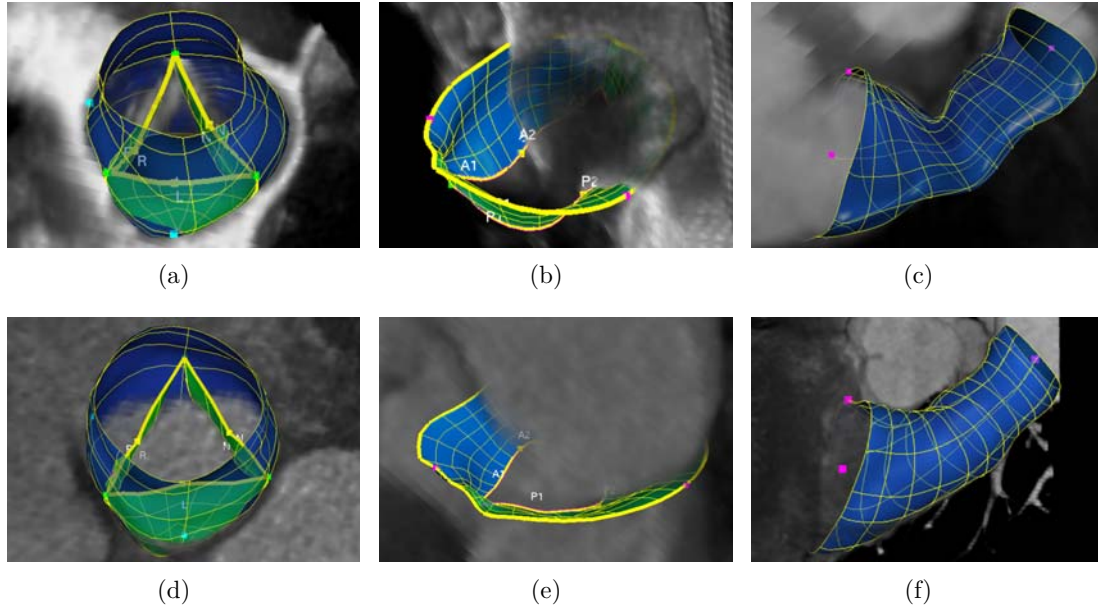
Examples of comprehensive valves model estimation: (a) aortic valve in TEE, (b) mitral valve in TEE, (c) pulmonary valve in CMR, (d) aortic valve in cardiac CT, (e) mitral valve in cardiac CT, and (f) pulmonary valve in cardiac CT.
